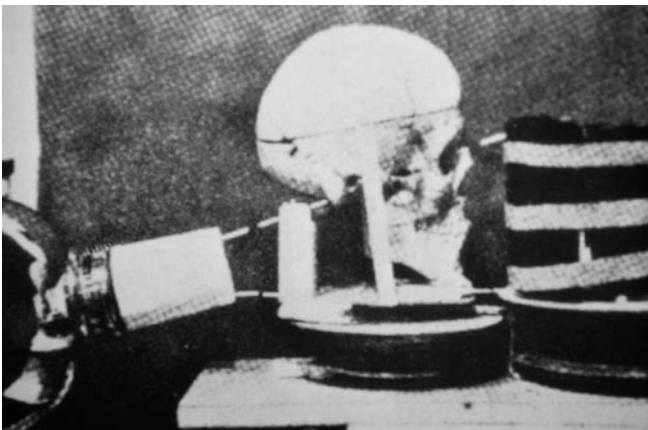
Beam path in the OPG (Reproduced from Langland O (1982) Principles and practice of panoramic radiology. Saunders, Philadelphia, p 17)
